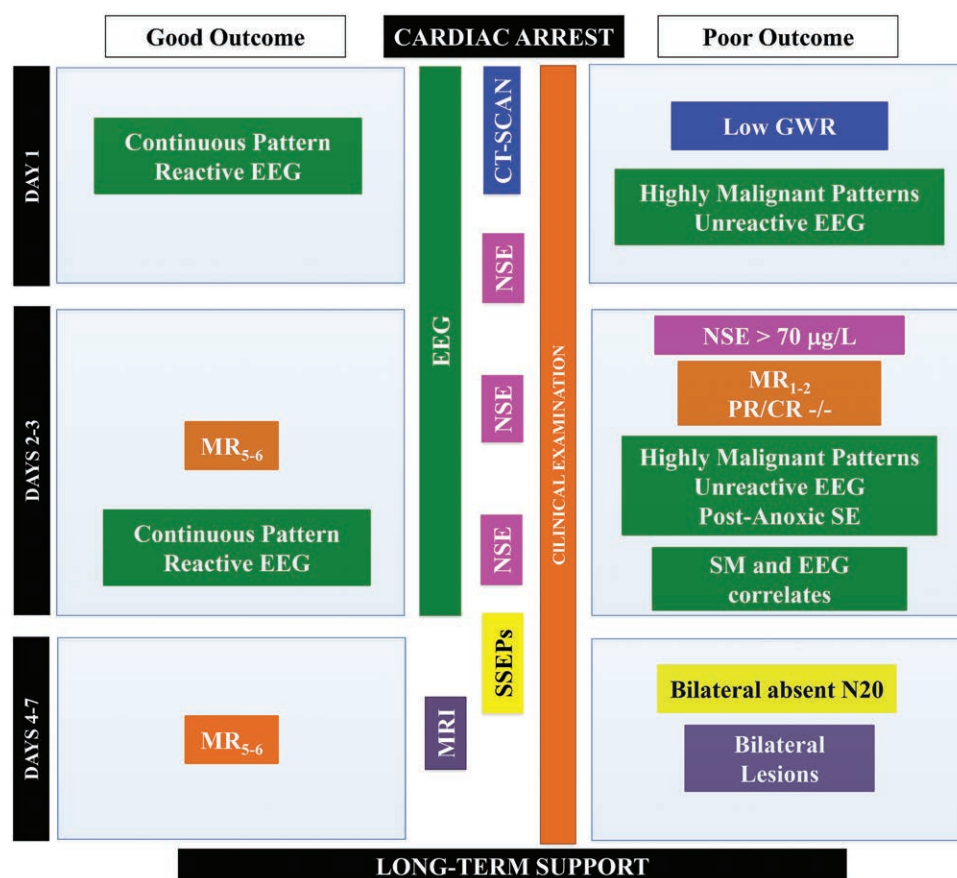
Multimodal approach for the prognostication of a neurologic outcome after cardiac arrest. CR, corneal reflexes; CT, computed tomography; EEG, electroencephalogram; GWR, gray to white matter ratio; MR, motor response; MRI, magnetic resonance imaging; MR_{1,2}, absent or posturing motor response; MR₅₋₆, localizing pain at stimuli or obeying orders; N20, cortical responses during SSEPs; NSE, neuron-specific enolase; PR, pupillary reflexes; SE, status epilepticus; SM, status myoclonus; SSEPs, somato-sensory-evoked potentials.
